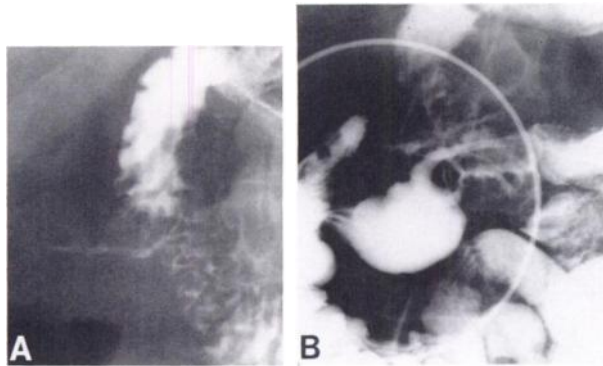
(A-B) A barium radiograph of the upper gastrointestinal tract with a small bowel follow-thru demonstrates one or more fistulae in the area of the neoterminal ileum to the duodenum. There is recurrent disease at the region of the anastomoses.
